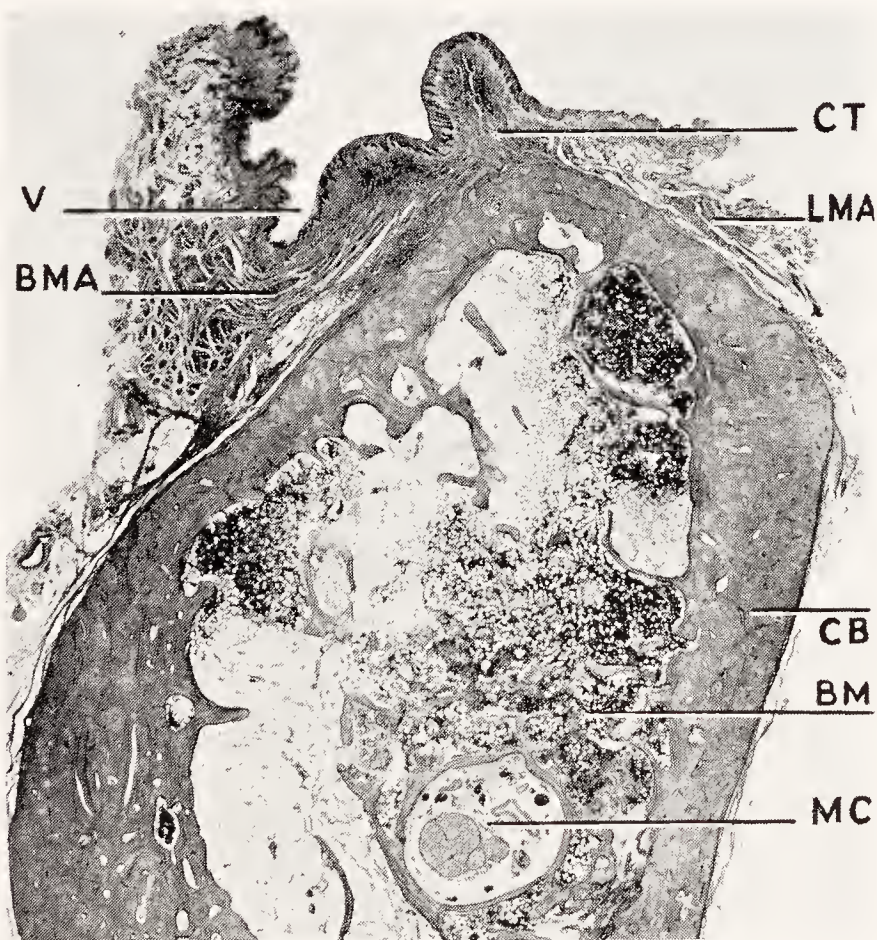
Bucco-lingual section through an edentulous mandible in the molar region. *V*, buccal vestibule; *BMA*, buccal muscle attachment; *CT*, connective tissue of residual ridge; *LMA*, lingual muscle attachment; *CB*, compact bone on the surface of the mandible; *BM*, bone marrow; *MC*, mandibular canal containing blood-vessels and nerves. (Courtesy of E. C. Pendleton.)
